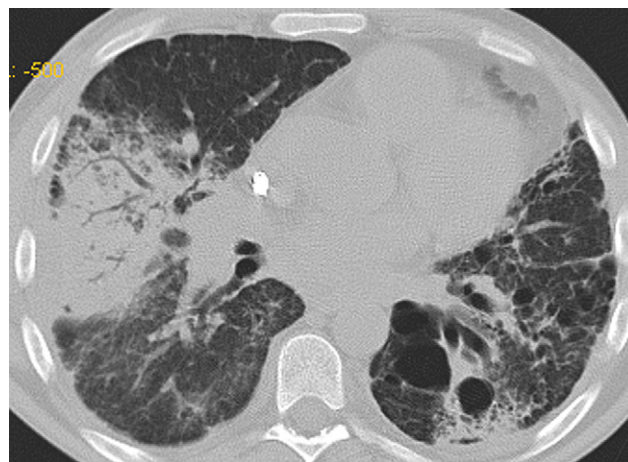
Spiral computed tomography scan of the chest shows consolidation with an air bronchogram in the lateral segment of the right upper lobe and surrounding ground glass opacities. There is an important destruction of the left lung parenchyma with cavities and bronchiectasis.
